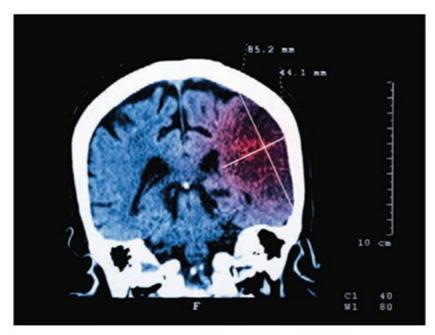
CT scan of the brain showing cerebral infarction (ischemic stroke). (stockdevil/Fotolia)
